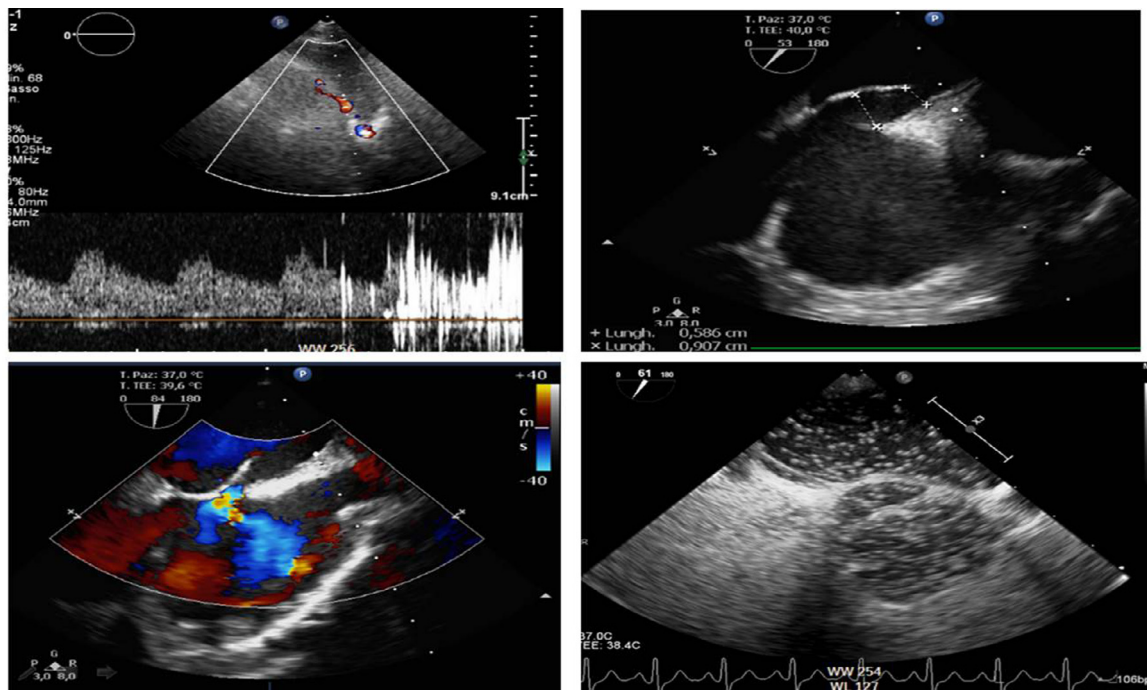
TOP LEFT: contrast transcranial Doppler (TCD) for the detection of right-to-left shunt. With patient in a supine position, the contrast agent is prepared using 9 ml of isotonic saline solution, 1 ml of air and 1 ml of patient's blood mixed with a three-way stopcock and injected as a bolus in the antecubital vein through an 18-gauge catheter. High intensity transient signals (HITS), defined as visible and audible short-duration, high-intensity signals within the Doppler flow spectrum, are recorded. The magnitude of right-to-left shunt is determined by counting the number of HITS in the middle cerebral artery in the first 40 s after bolus infusion and by applying the four-level visual categorization of the International Consensus Criteria. In this case grade III: curtain pattern (Adams et al., 1993) or grade \geq III: >30 signals (Spencer et al., 2004¹⁷). TOP RIGHT: Transoesophageal echocardiography (TOE) short axis view (53°) showing the right atrium (RA) down, the left atrium (LA) up, and the aorta on the right. The patent foramen ovale (PFO) is a huge tunnel measuring 9 mm in the right side and 5.8 mm in the left side. Bottom Left: TOE long axis view (84°) showing the right atrium (RA) down, the left atrium (LA) up, and the superior caval vein on the right. The color Doppler demonstrates a left-to-right shunt through the PFO in basal condition. Bottom Right: TOE short axis view (61°) with contrast injection showing the RA on the left, the LA up and right and the aorta down and right. After the RA is completely filled with contrast bubbles there is a severe shunt of contrast into the LA across the PFO.
